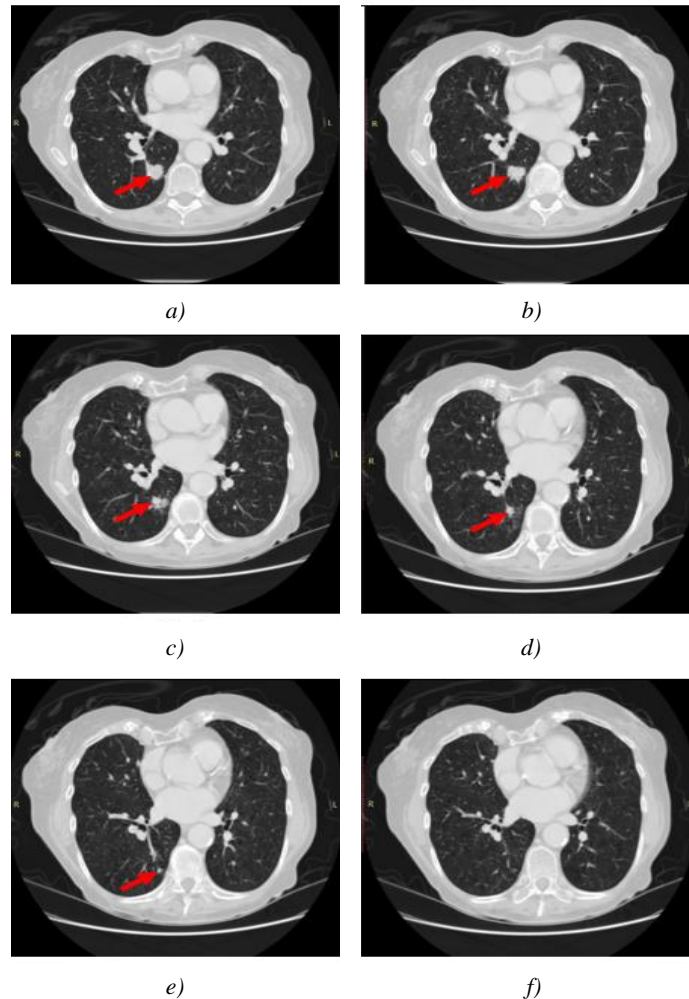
Original CT Lung scan between Slice 60 and 64 with a Red arrow to indicate Two Attached Nodules: *a* — Candidate Nodule in the 60th slice; *b, c, d* — lung Nodules through slices 61, 62, 63; *e* — Nodule in slice 64; *f* — Normal slice after slice 65
